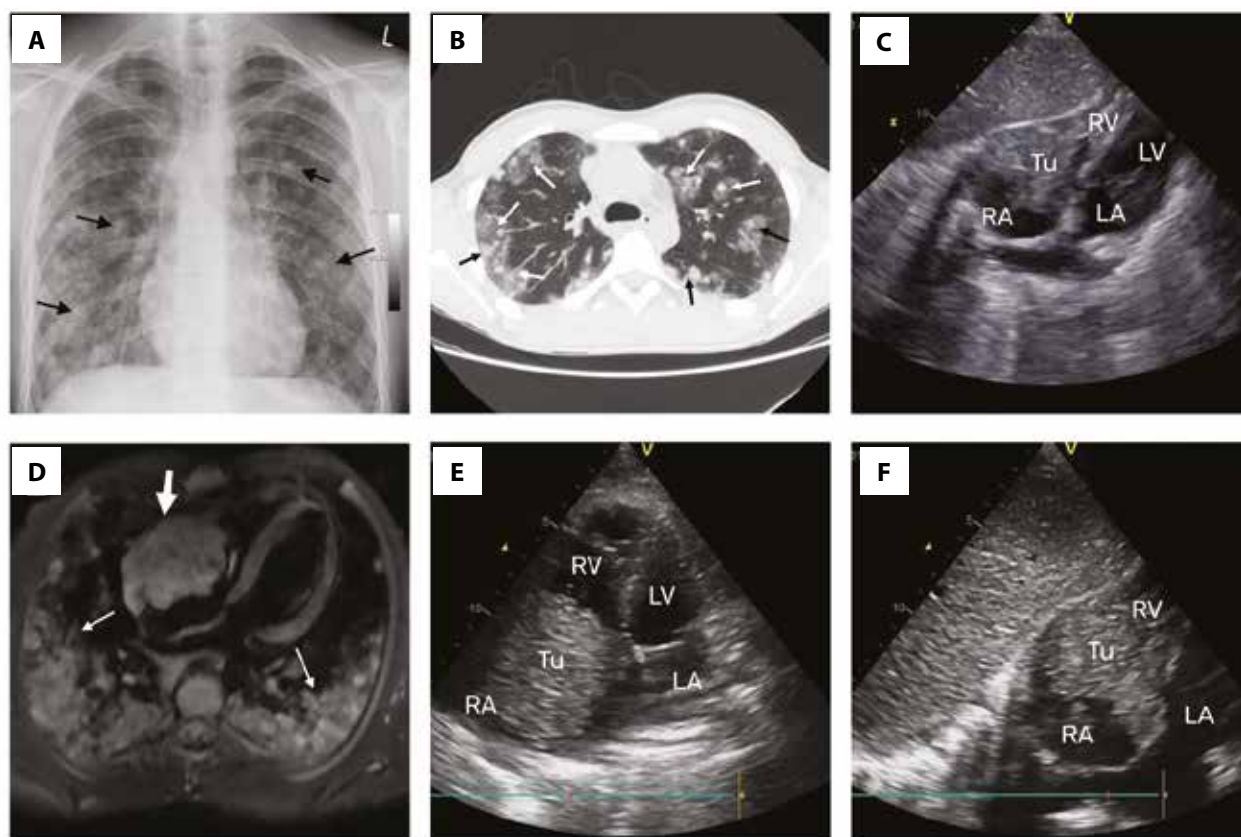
Multimodality imaging of cardiac angiosarcoma. A. X-ray of the lungs showing diffuse ground-glass opacities (black arrows). B. Computed tomography of the lungs showing ground-glass opacities in the center and periphery (white arrows) and subpleural opacifications (black arrows). C. Initial TTE, subcostal view showing a large right atrial tumor with a possible thrombus on the periphery. D. T1-weighted magnetic resonance imaging showing lesion in the right atrium of the heart (thick arrow) and metastatic lesions in both lungs (thin arrows). E. TTE after 2 weeks, apical 4-chamber view showing the tumor mass encroaching RA and infiltrating the free wall. F. TTE after 2 weeks, subcostal view, showing the enlargement of the tumor mass.
